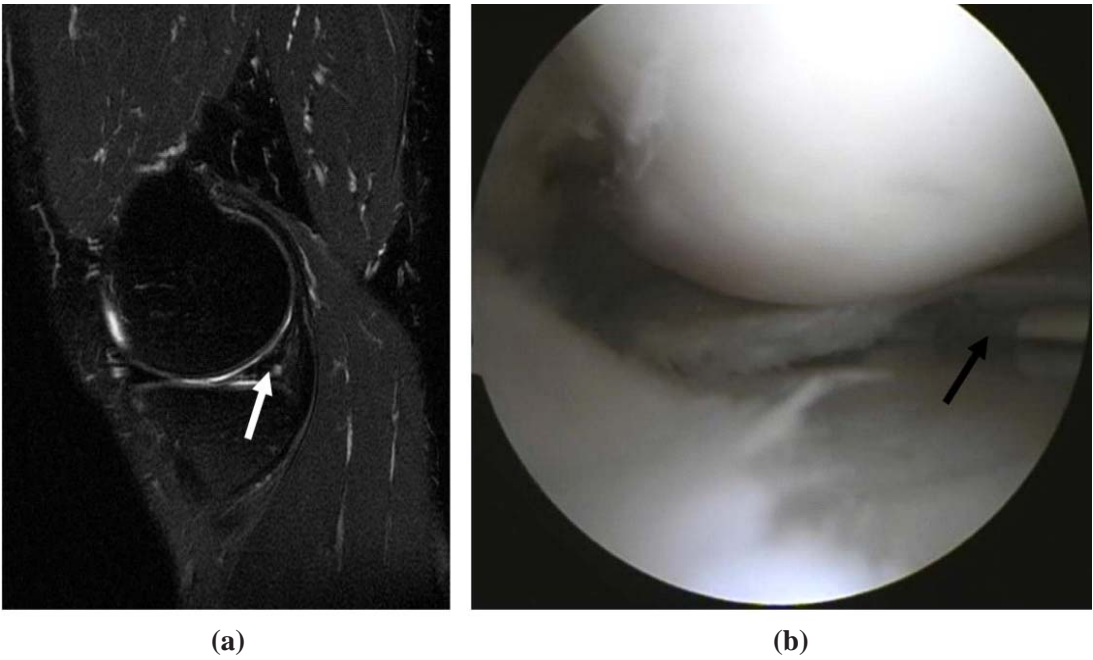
A 52-years-old man. There was high intrameniscal signal extending to articular surface (indicated by a white arrow) at posterior horn of medial meniscus on sagittal T2-weighted image with fat suppression (a). Knee arthroscopy showed meniscal tear (indicated by a black arrow) at the same region (b).
